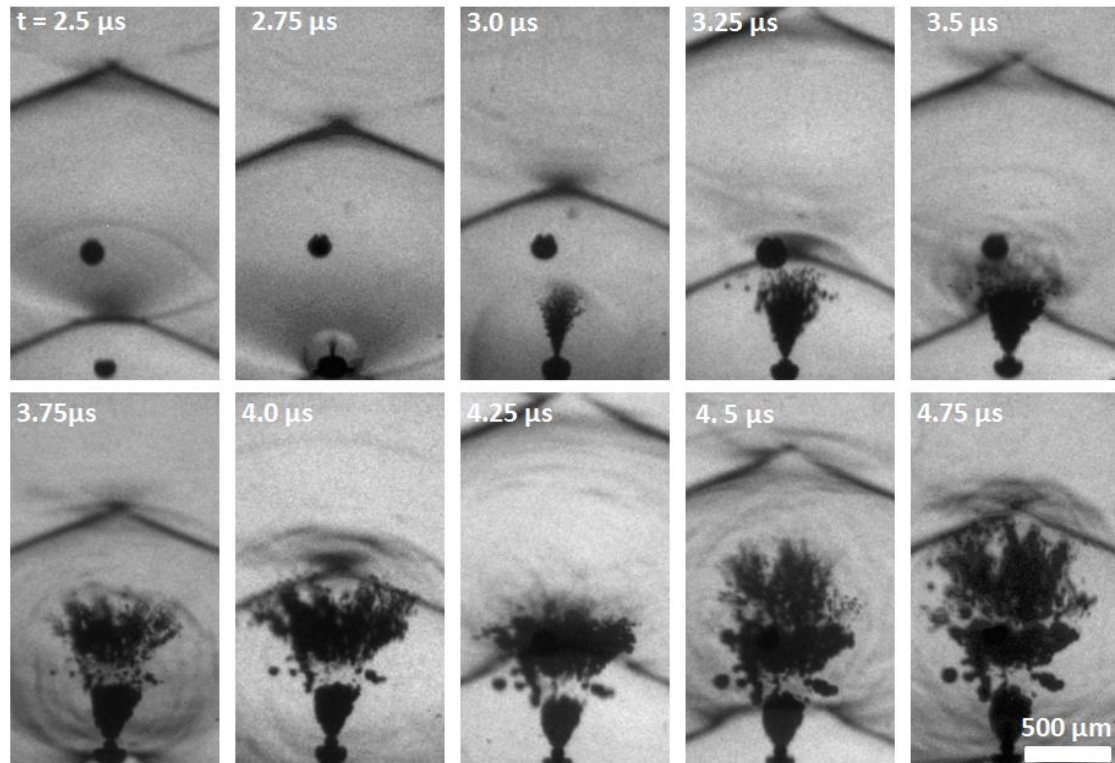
Initiation of a bubble cloud. Ultrasound propagation was from top to bottom. At $t = 2.5 \mu\text{s}$, a single bubble was present at the right side of the frame. After the shock impinged on the bubble ($t = 2.75 \mu\text{s}$), a spherical wave was visible, apparently scattered by the bubble. Over the next cycle, a cloud of bubbles stemmed from the center of the single bubble behind this scattered wave. A second cycle produced another section of the cloud between $t = 3.5 \mu\text{s}$ and $t = 4.0 \mu\text{s}$, and a third section was produced between $t = 4.25 \mu\text{s}$ and $t = 4.75 \mu\text{s}$. The timing in this figure corresponded to that in Figure 2.2 with the waveform at the position of the initial bubble.
